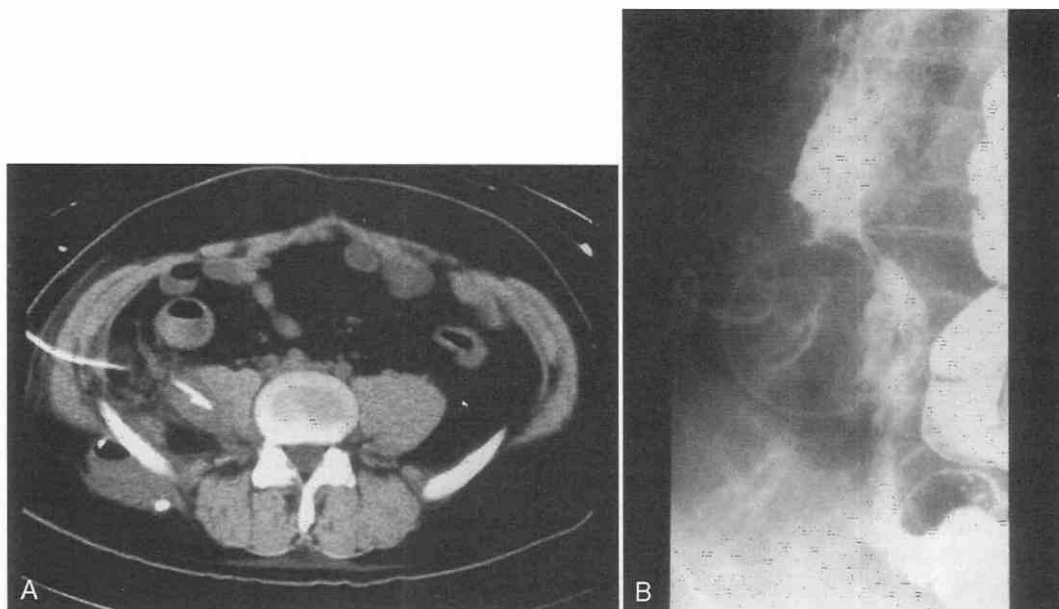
A*, CT scan shows two abscess cavities in the right side: one in the psoas muscle and one in the gluteus muscle behind the iliac crest. The high-density objects are cross-sections of two different catheters that were used to drain the abscesses. *B*, A sinogram taken later in the course of the patient's recovery shows communication of the long cavity in the psoas muscle with the small bowel. Total resolution without surgery followed (see text).
